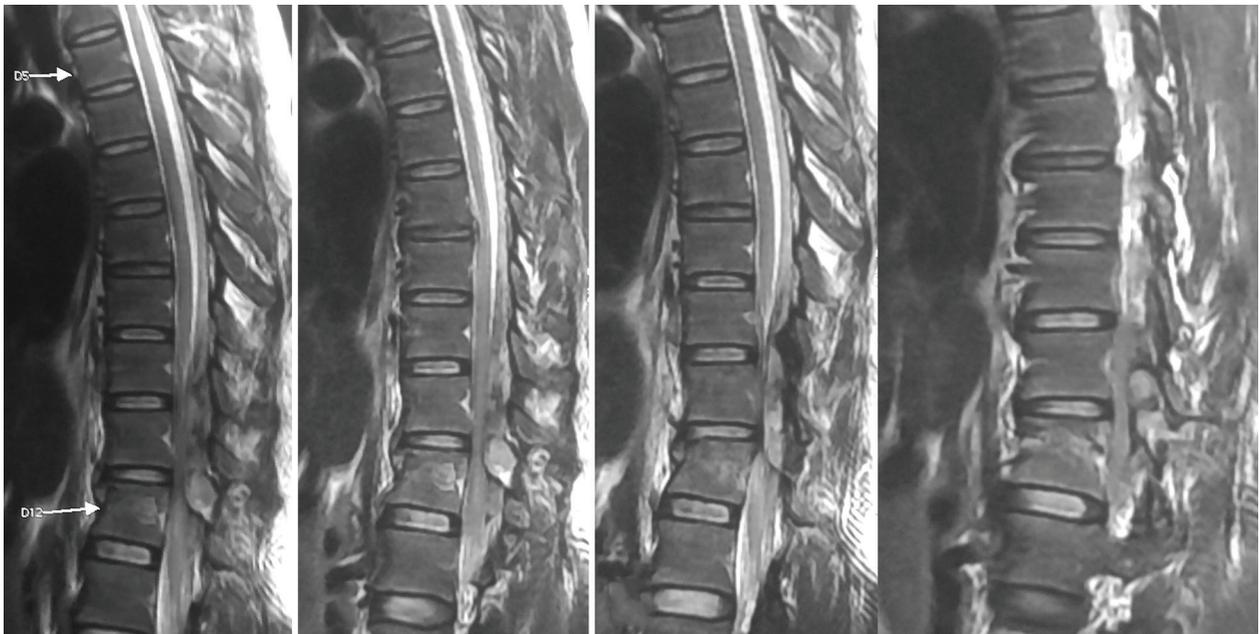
Sagittal T2-weighted MRI images of dorsal spine shows fracture of D12 vertebral body with posterior epidural hematoma appearing heterogeneously hyperintense to the cord, with few tiny hyperintense areas within, causing mass effect on the cord and loss of epidural fat. Mild cord edema also can be seen at this level. MRI, magnetic resonance imaging.
